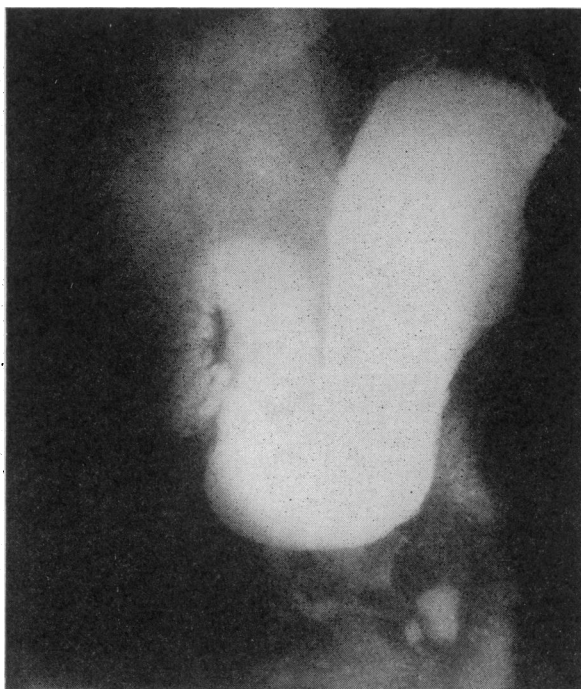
Roentgenogram, Case 1, showing chronic duodenal stasis.
